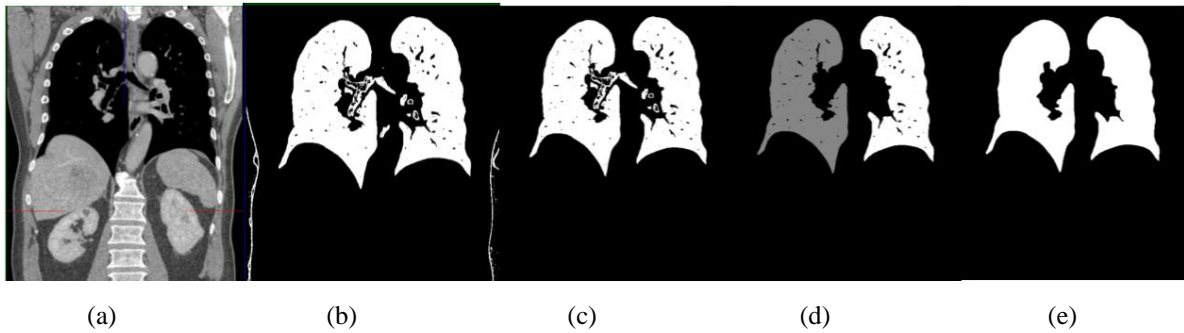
The generation process of lung mask. (a) Original CT image (b) Threshold operation (c) 3D labeling (d) 2D labeling on frontal view (e) Final lung mask after hole filing filter
